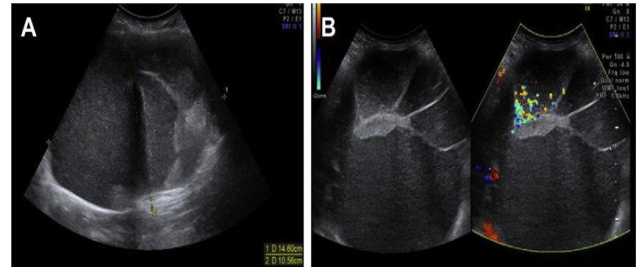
A 28-Year-old pregnant female, Ultrasound of pancreatic mucinous cystic neoplasm (MCN) performed in the ninth week of gestation. (A) Abdominal ultrasound demonstrating a large cystic mass (14 cm x 11 cm) with septations and mural nodules. (B) Blood flow was present around the mural nodule and a hypertrophic septum in the tumor.
